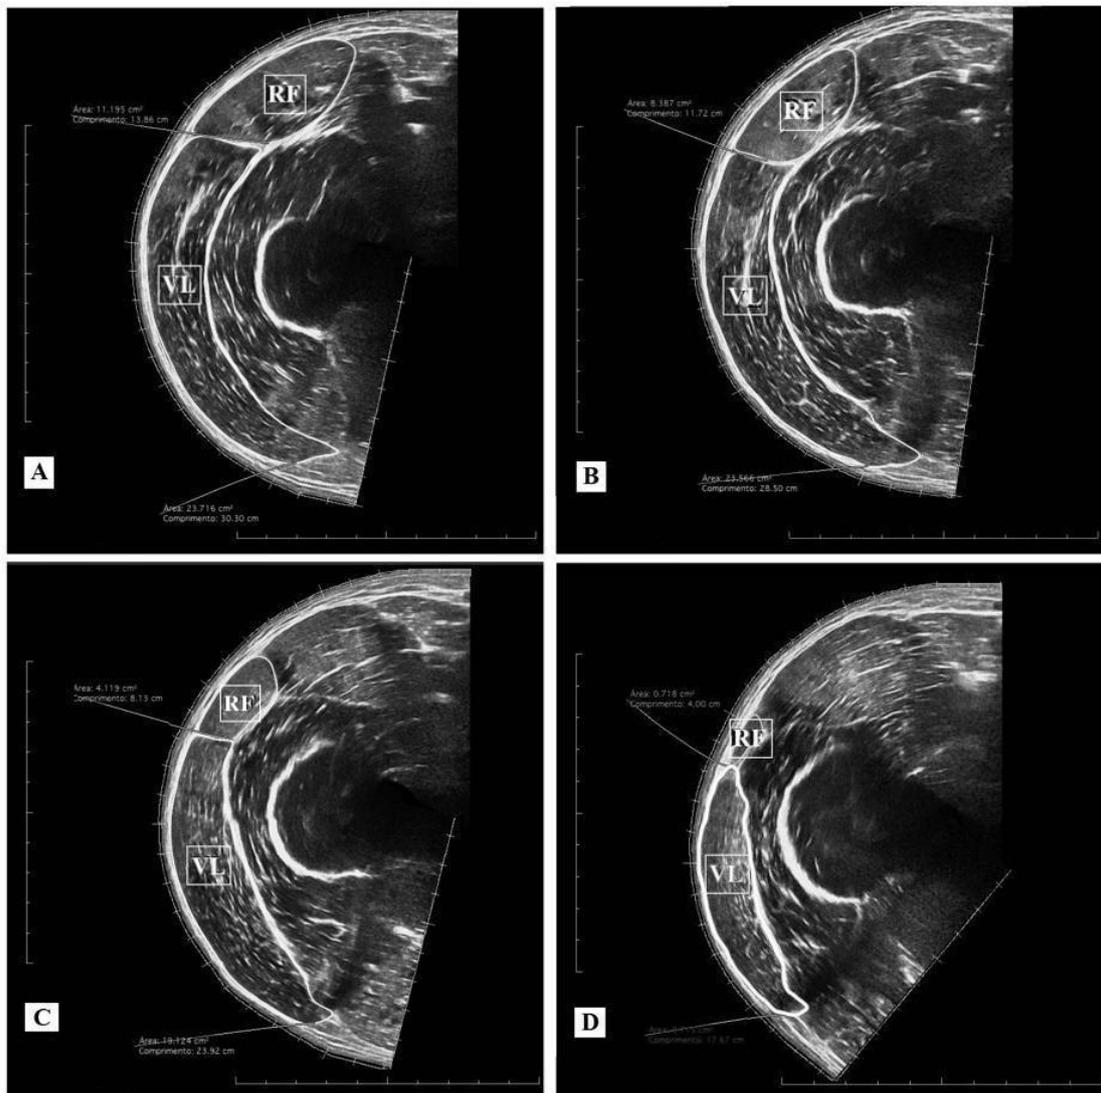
Ultrasound images and cross-sectional areas (CSA) at 40% (A); 50% (B), 60% (C), and 70% (D) of femur length. Rectus femoris (RF) and vastus lateralis (VL).
